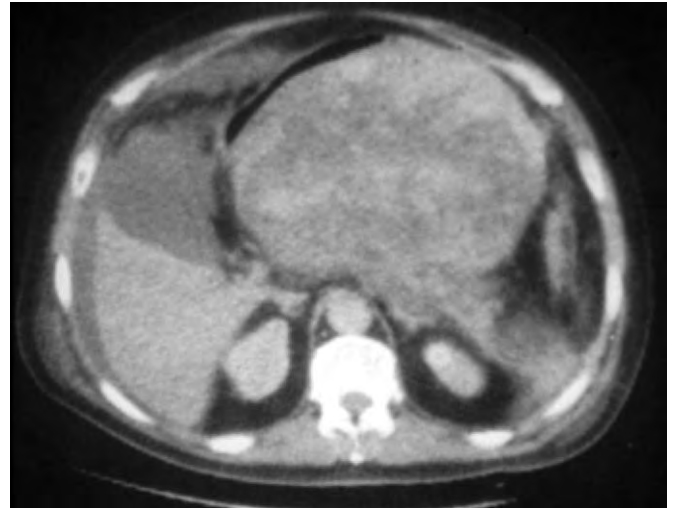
Hemorrhage into a pseudocyst can be detected on a CT scan that shows a large collection of fluid that has high density (fresh blood) within the fluid collection. (From Simms M, Johnson D: Diagnosis of necrotizing pancreatitis using contrast material-enhanced CT. *Probl Gen Surg* 13:17, 1996.)
